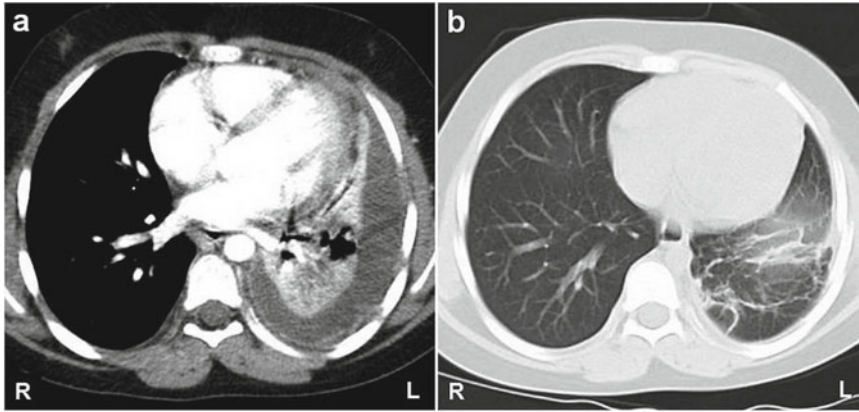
Chest CT; (a) Extensive interstitial-alveolar changes in the left lung with atelectasis and pleural effusion (Day 5); (b) Resolution of changes after 20 days of treatment
